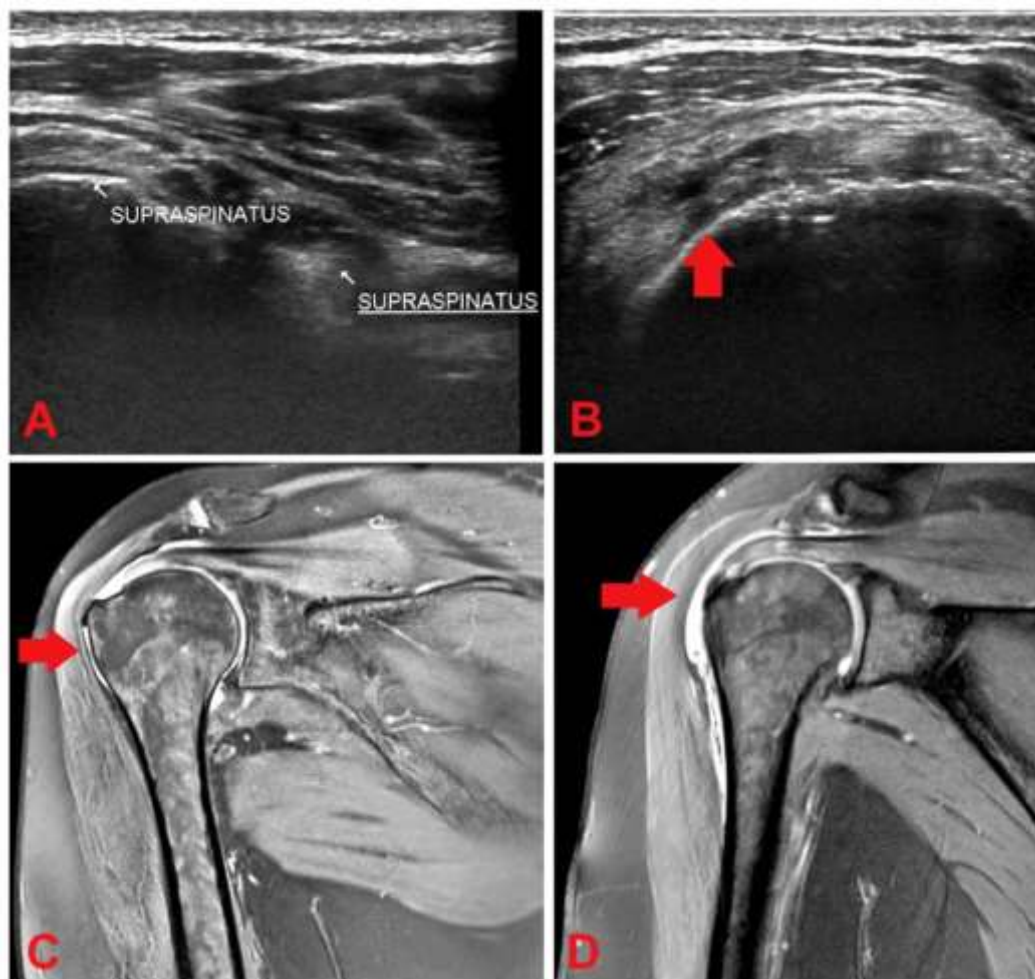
Comparison of ultrasonography (A, B) and MRI (C, D) in a representative patient with supraspinatus tendon abnormality. USG images (A, B) show the supraspinatus tendon with an area of altered echotexture (arrow in B) corresponding to tendon abnormality, while the corresponding MRI images (C, D) demonstrate the same pathology (arrows) with superior soft-tissue contrast.
